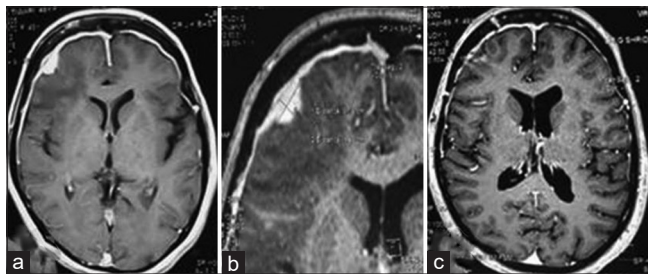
(a and b) Magnetic resonance imaging brain fluid-attenuated inversion recovery showing right frontal lesion which on contrast administration showed nodular pachymeningeal enhancement (Patient 6). (c) Repeat magnetic resonance imaging after 6 months showing complete resolution. The patient was on rituximab
